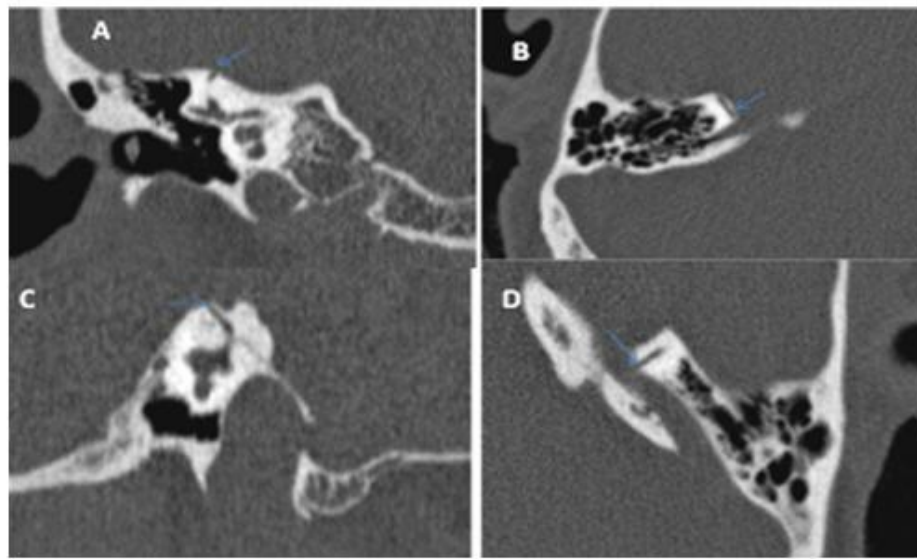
A 48 years old male patient complaining of vertigo CT temporal bones revealed: Bilateral SSCD which was detected in 5 mm interval coronal images (A) right side dehiscence (arrowed) and (C) left side dehiscence (arrowed). SSCD was also detected in axial planes on the right side (arrowed) (B) and it measured 2.4 mm and on the left side (arrowed) (D) and it measured 2.7 mm.
